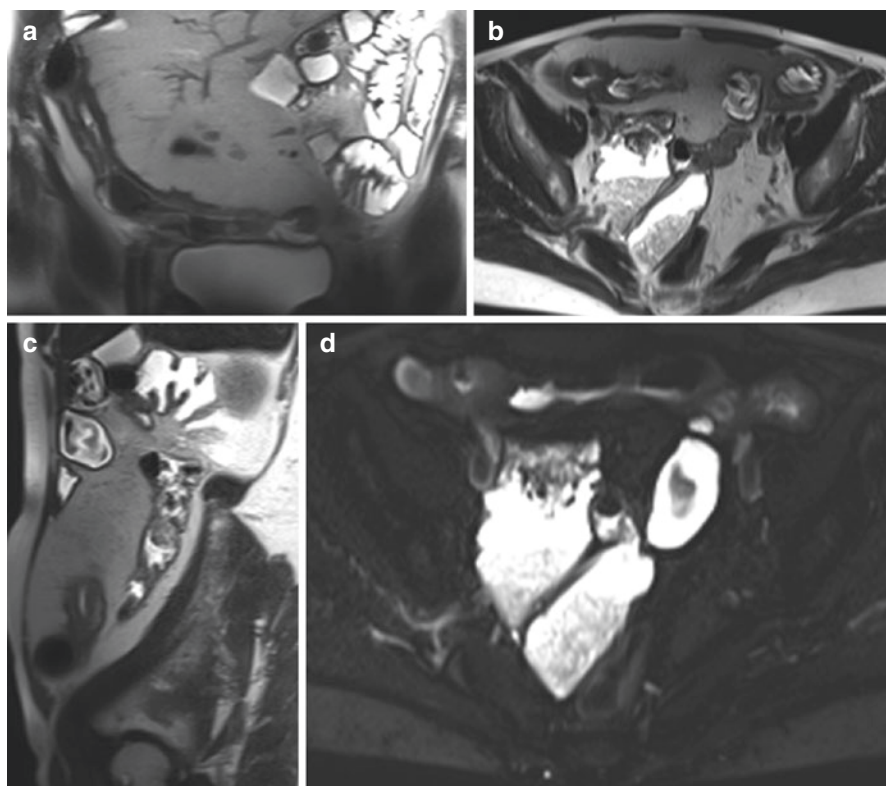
(a) Coronal, (b) axial, and (c) sagittal planes in a T2-W sequence showing a distal ileum involvement of CD with stenosis, wall thickening, submucosal edema, and perivisceral fat stranding. (d) T2-W FS shows submucosal edema. MRI findings are consistent with active inflammation
